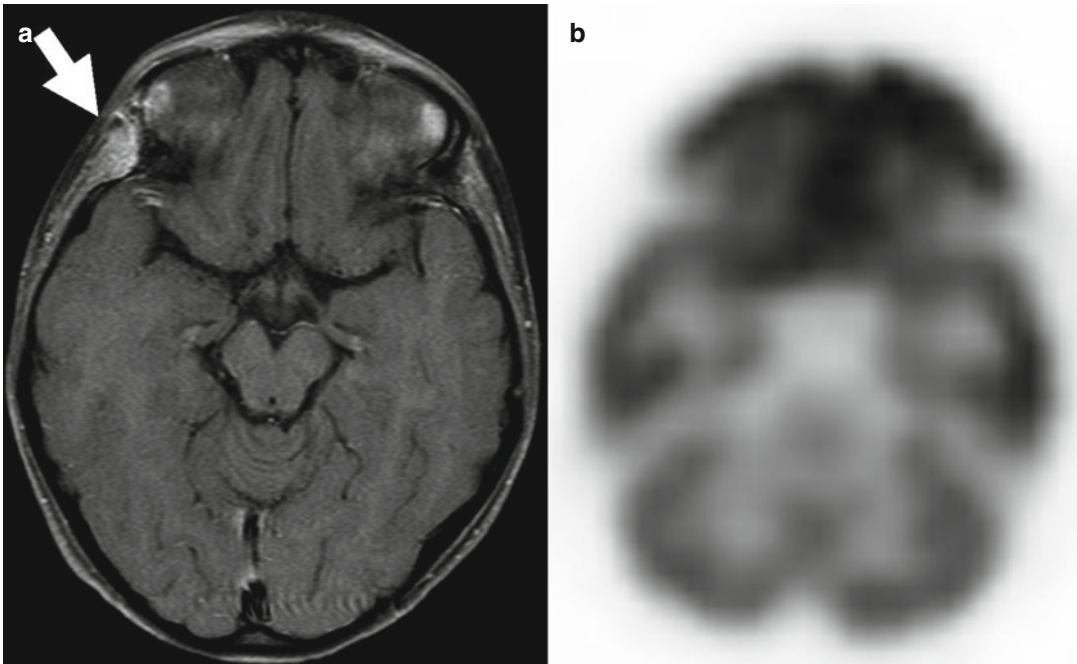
Eosinophilic granuloma of the right frontal skull base in a 19-year-old boy on separate PET and MRI scans. A contrast-enhancing lesion of the right frontal skull base is seen on T1-weighted MRI images (arrow) (a). Corresponding PET images show normal uptake
